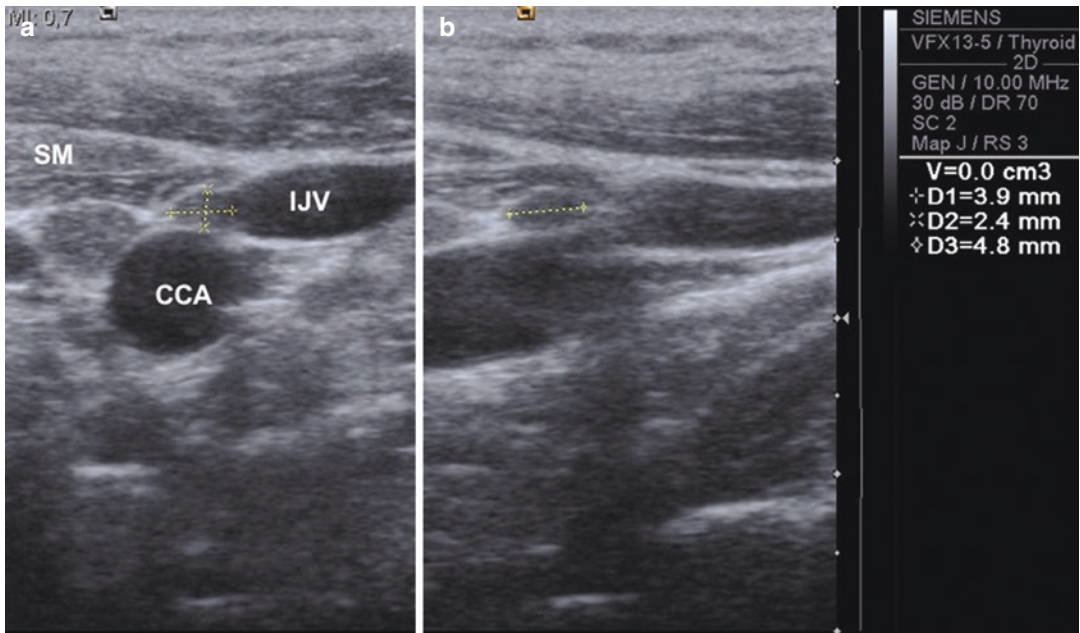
Axial (a) and longitudinal (b) sonograms of residual thyroid tissues in left thyroid bed as three different foci (hair-cross). *SM* strap muscles, *Tr* trachea, *IJV* internal jugular vein, *CCA* common carotid artery
